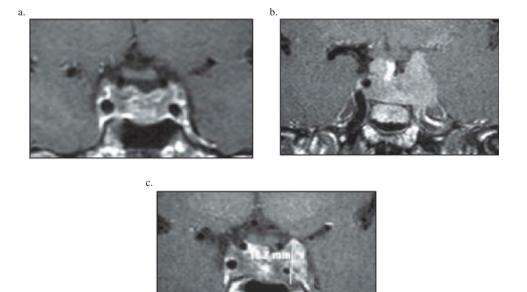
Coronal T1-weighted pituitary MRI in patient with a DA-resistant prolactinoma treated with temozolomide. [A] In 1995, after pituitary surgery, showing postoperative sequellae without any large visible residual adenomatous tissue. [B] In 2006, showing a relapse of the tumor with a large adenomatous residue in the left cavernous sinus. [C] In 2011, after 24 sessions of temozolomide (given between 2006 and 2008) with prolactin decreasing from 6950 to 98 ng/mL and the tumor volume from 62%, at the last follow-up.
